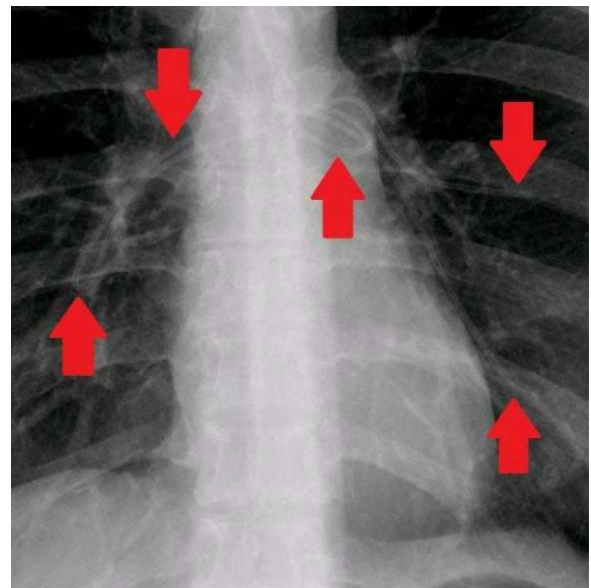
Chest x-ray. Focused view of the mediastinal shadow. Red arrows indicate an unexplained abnormal linear structure.
